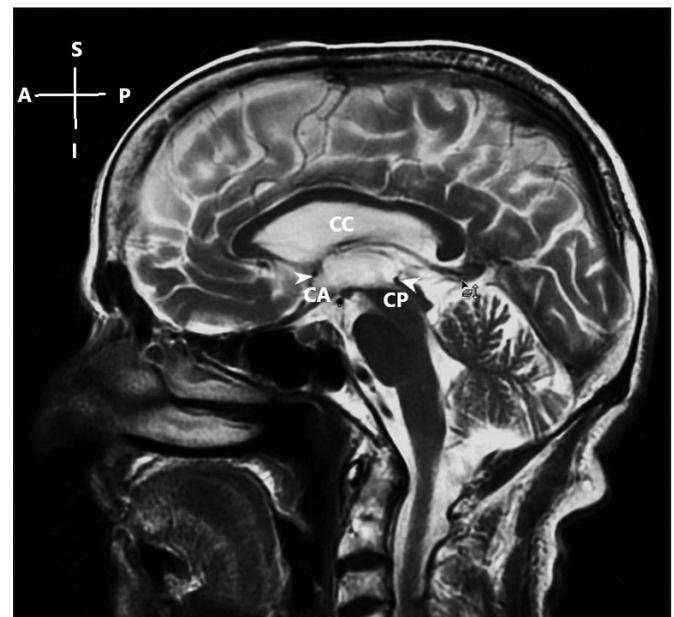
T2W MR image of left cerebral hemisphere without interthalamic adhesion. CA: Anterior commissure; CP: Posterior commissure; CC: Corpus callosum; A: Anterior; P: Posterior; S: superior; I: Inferior.
